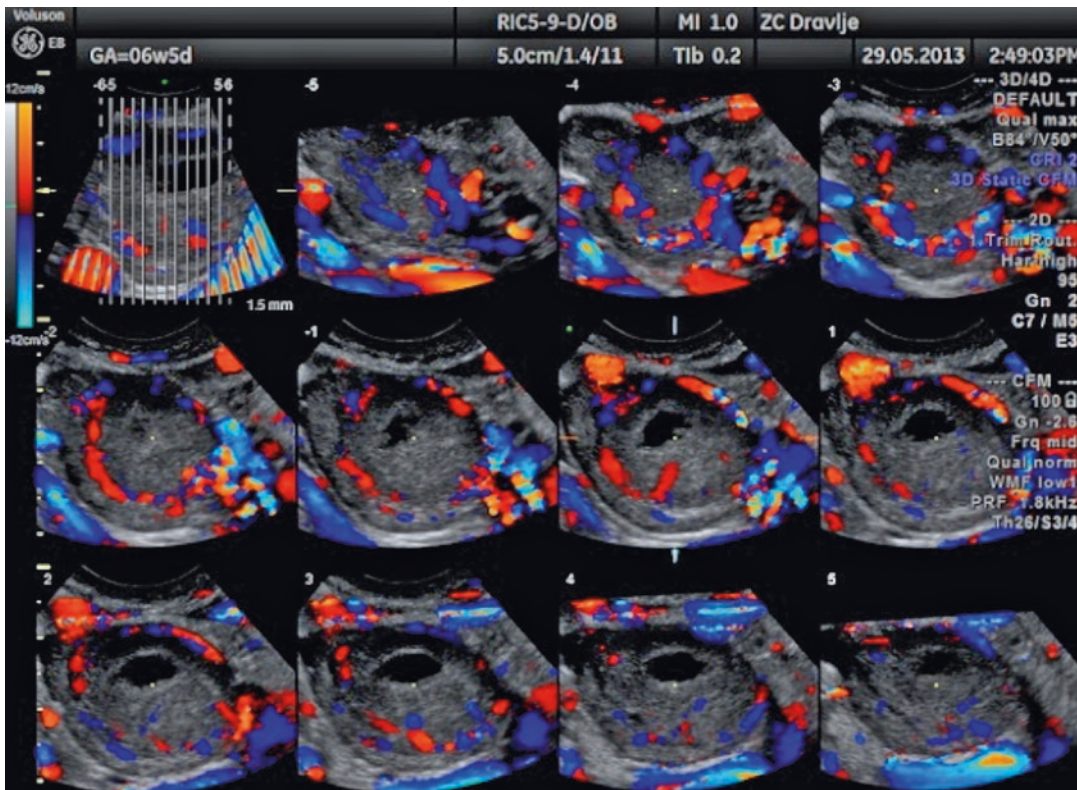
Color Doppler image of vascularization of the corpus luteum
